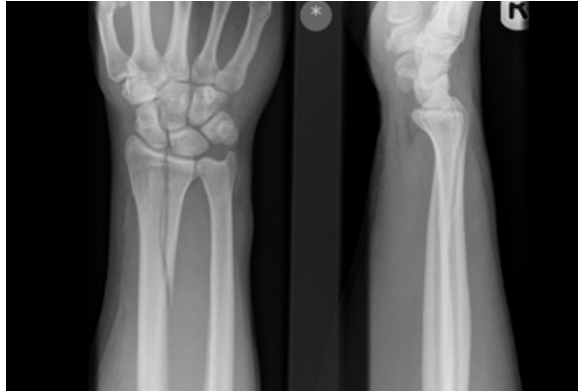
AP and lateral radiographs, showing vertical fracture of distal radius
